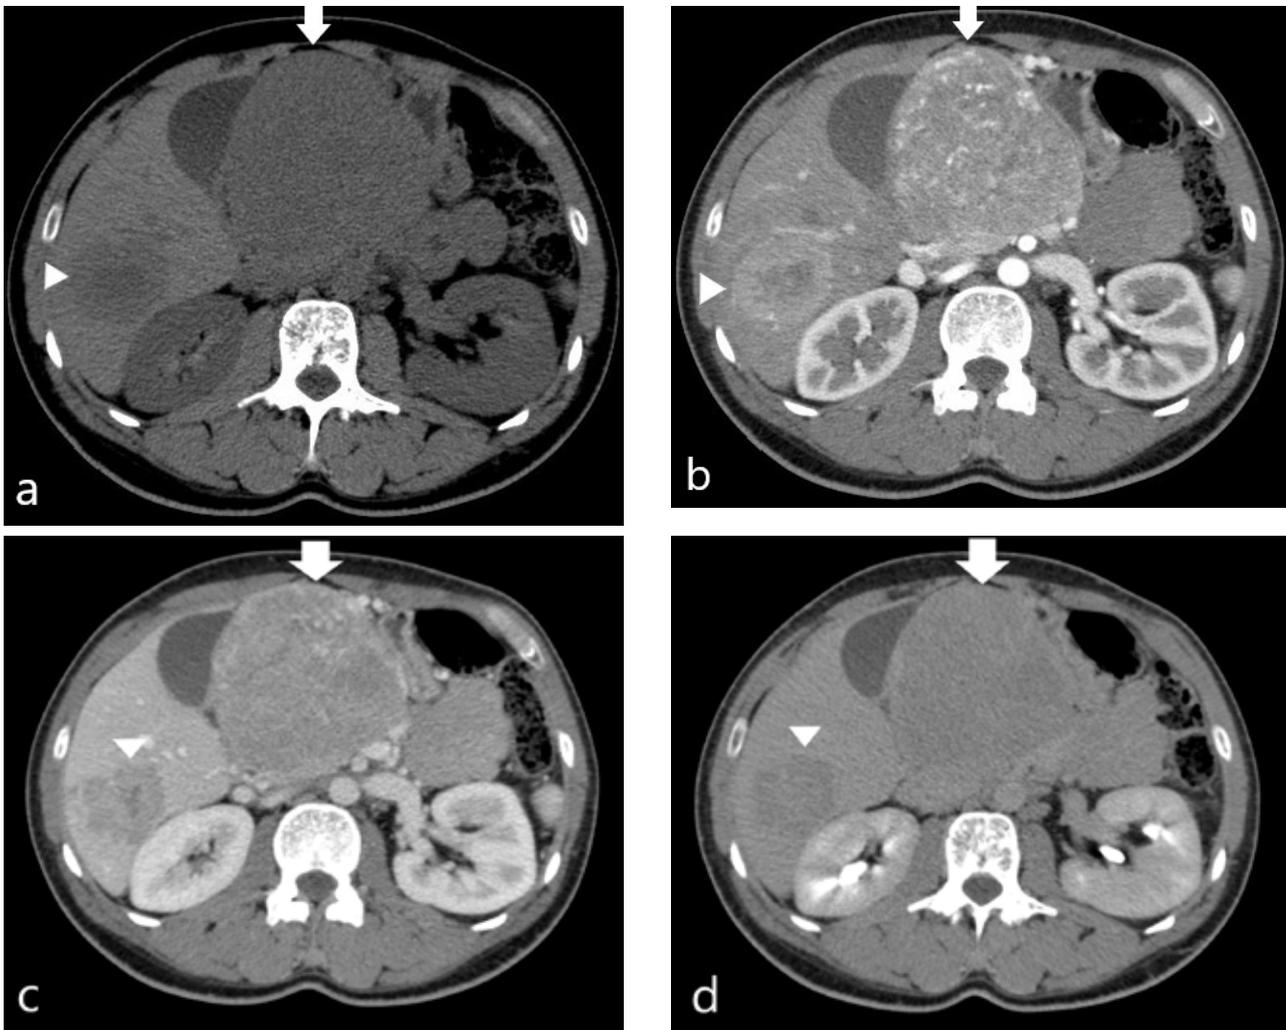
(a) Axial unenhanced CT shows a large heterogeneous pancreatic mass (arrow) and a liver lesion (arrowhead) in segment VI. The liver mass lesion appears also inhomogeneous, mainly hypodense when compared to normal liver parenchyma. (b) Axial arterial contrast-enhanced CT image shows both pancreatic and liver lesions avidly and heterogeneously enhancing. Both lesions de-enhance in portal (c) and delayed (d) phases. Imaging findings were suggestive of a neuroendocrine tumour of the pancreas with liver metastasis and were subsequently confirmed on pathology.
